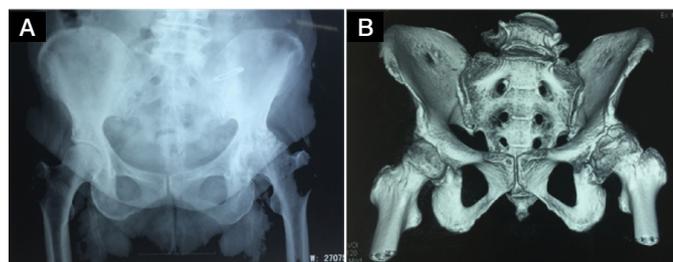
Preoperative pelvic X-ray (A); preoperative CT scan+3D reconstruction (B).
